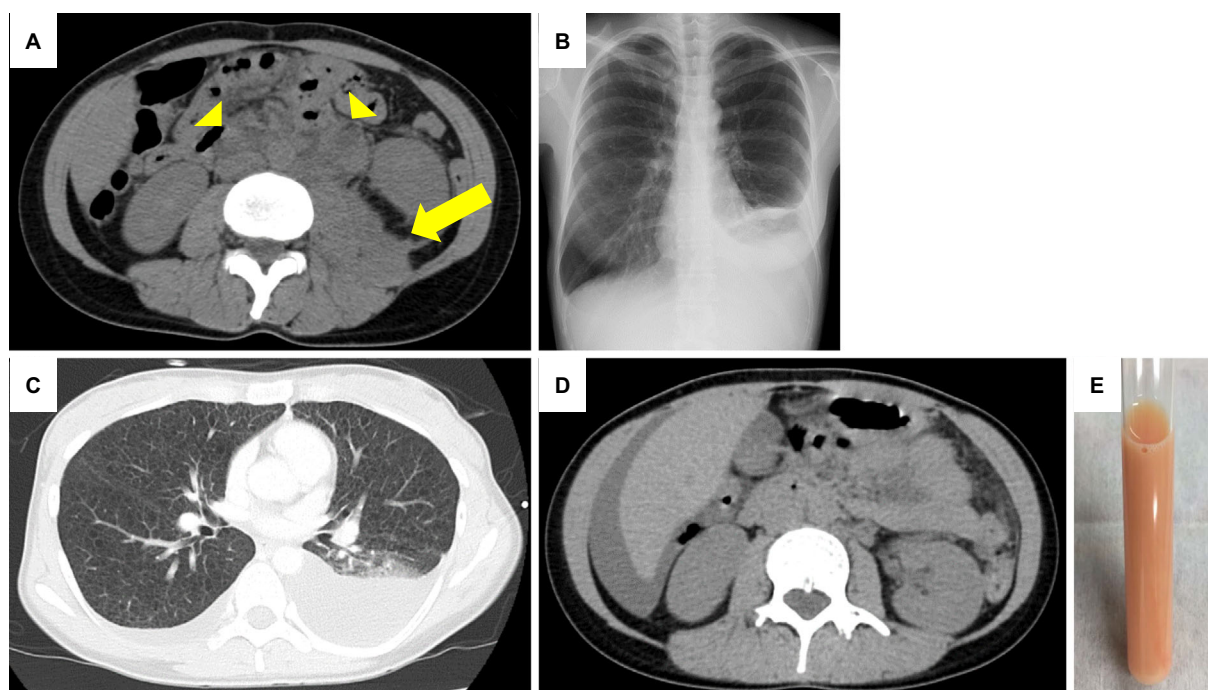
Radiologic findings of the abdomen (A and D) and chest (B and C). (A) Computed tomography (CT) of the abdomen in April 2012 showed left retroperitoneal solid tumor (arrow) and peri-aortic lymphadenopathy (arrow head). (B) Chest radiography in January 2015 demonstrated left-sided pleural effusion, and (C) Chest CT showed multiple thin-walled cysts in the both lung fields and bilateral asymmetry pleural effusion, superior to left side. (D) Abdominal CT in January 2015 showed regression of retroperitoneal tumor and lymphadenopathy, whereas ascites emerged. (E) Appearance of the pleural effusion was pale yellow-brown, cloudy.
